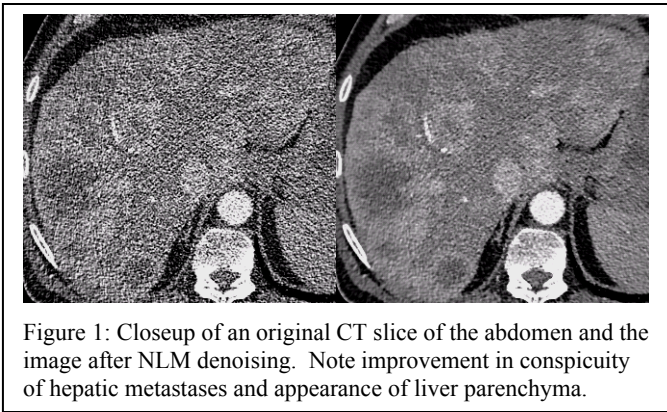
Closeup of an original CT slice of the abdomen and the image after NLM denoising. Note improvement in conspicuity of hepatic metastases and appearance of liver parenchyma.
